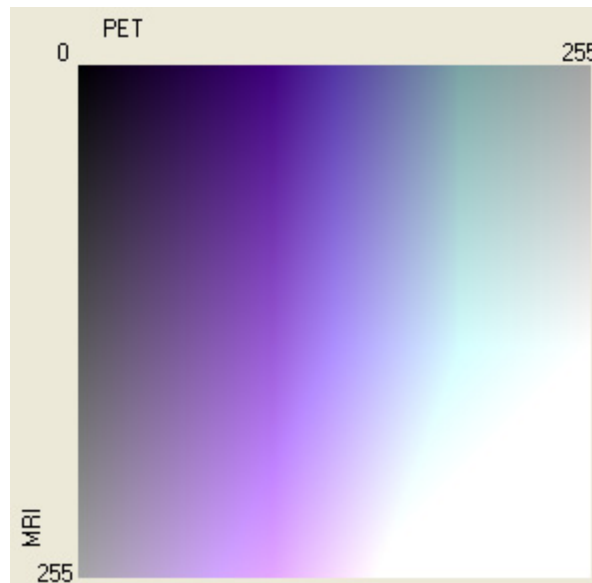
Resulting two-dimensional look up table from fusion scheme used to create the joint MRI/PET images shown in Figure 2.34, Figure 2.35, and Figure 2.36.
